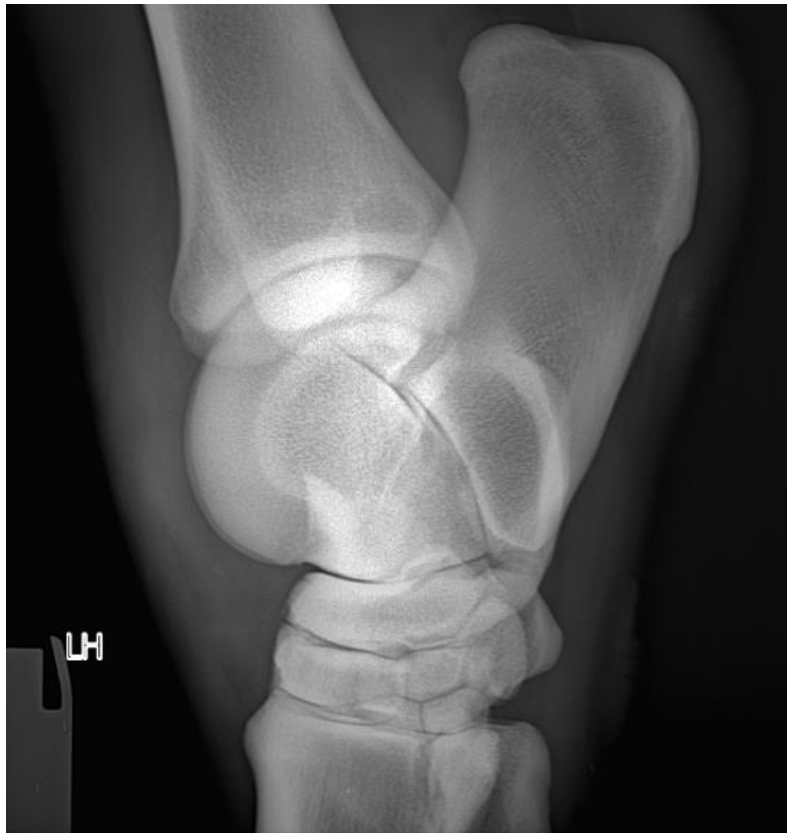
DR x-ray lateromedial view image.
